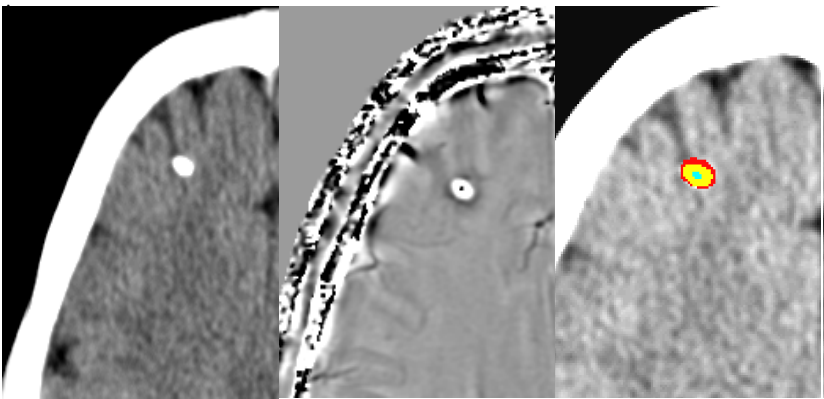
Showing CT, Filtered phase image showing both positive & negative phase, and segmented calcified cyst overlaid on CT image, cyan representing scolex, yellow-body of the cyst and red- showing brain tissue surrounding the cyst
